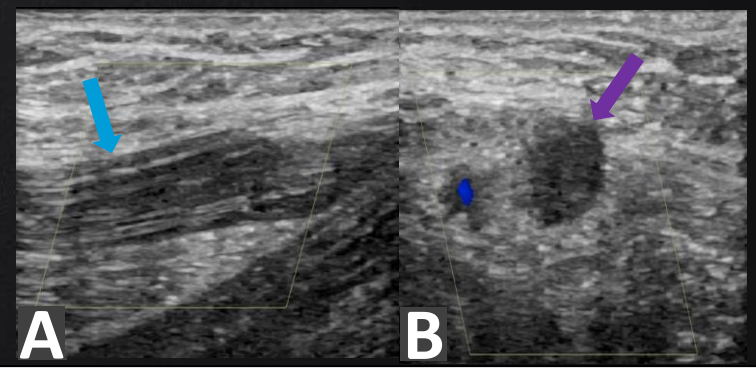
90-year-old woman presents with asymmetric edema on right arm 3 days after insertion of peripherally inserted central catheter (PICC). Left image shows absence of Doppler flow (A) - (blue arrow) pericatheter in the right basilic vein. Right image demonstrate absence of compressibility (B) - (purple arrow) in this vein, compatible with acute thrombosis.
